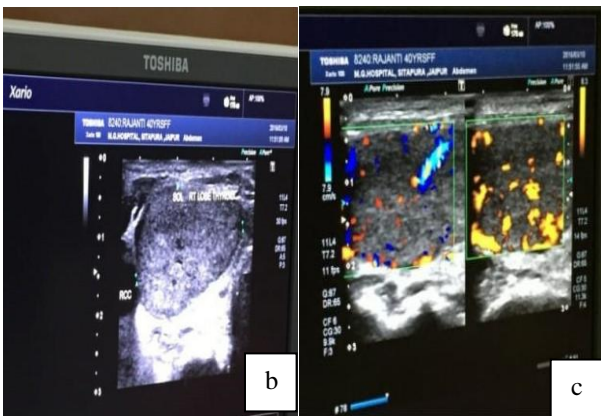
(a): Grey scale image shows right lobe of the thyroid shows well-defined heterogeneous nodules with sonolucent rim; (b) on Doppler increased peripheral and internal vascularity seen around the nodules.
